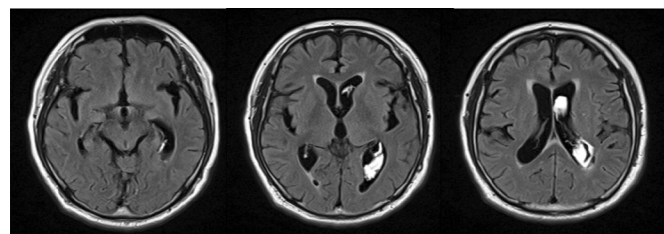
The fluid-attenuated inversion recovery MRI taken on admission. There was no vascular abnormality in the ventricle wall and no parenchymal lesion in the midbrain.
